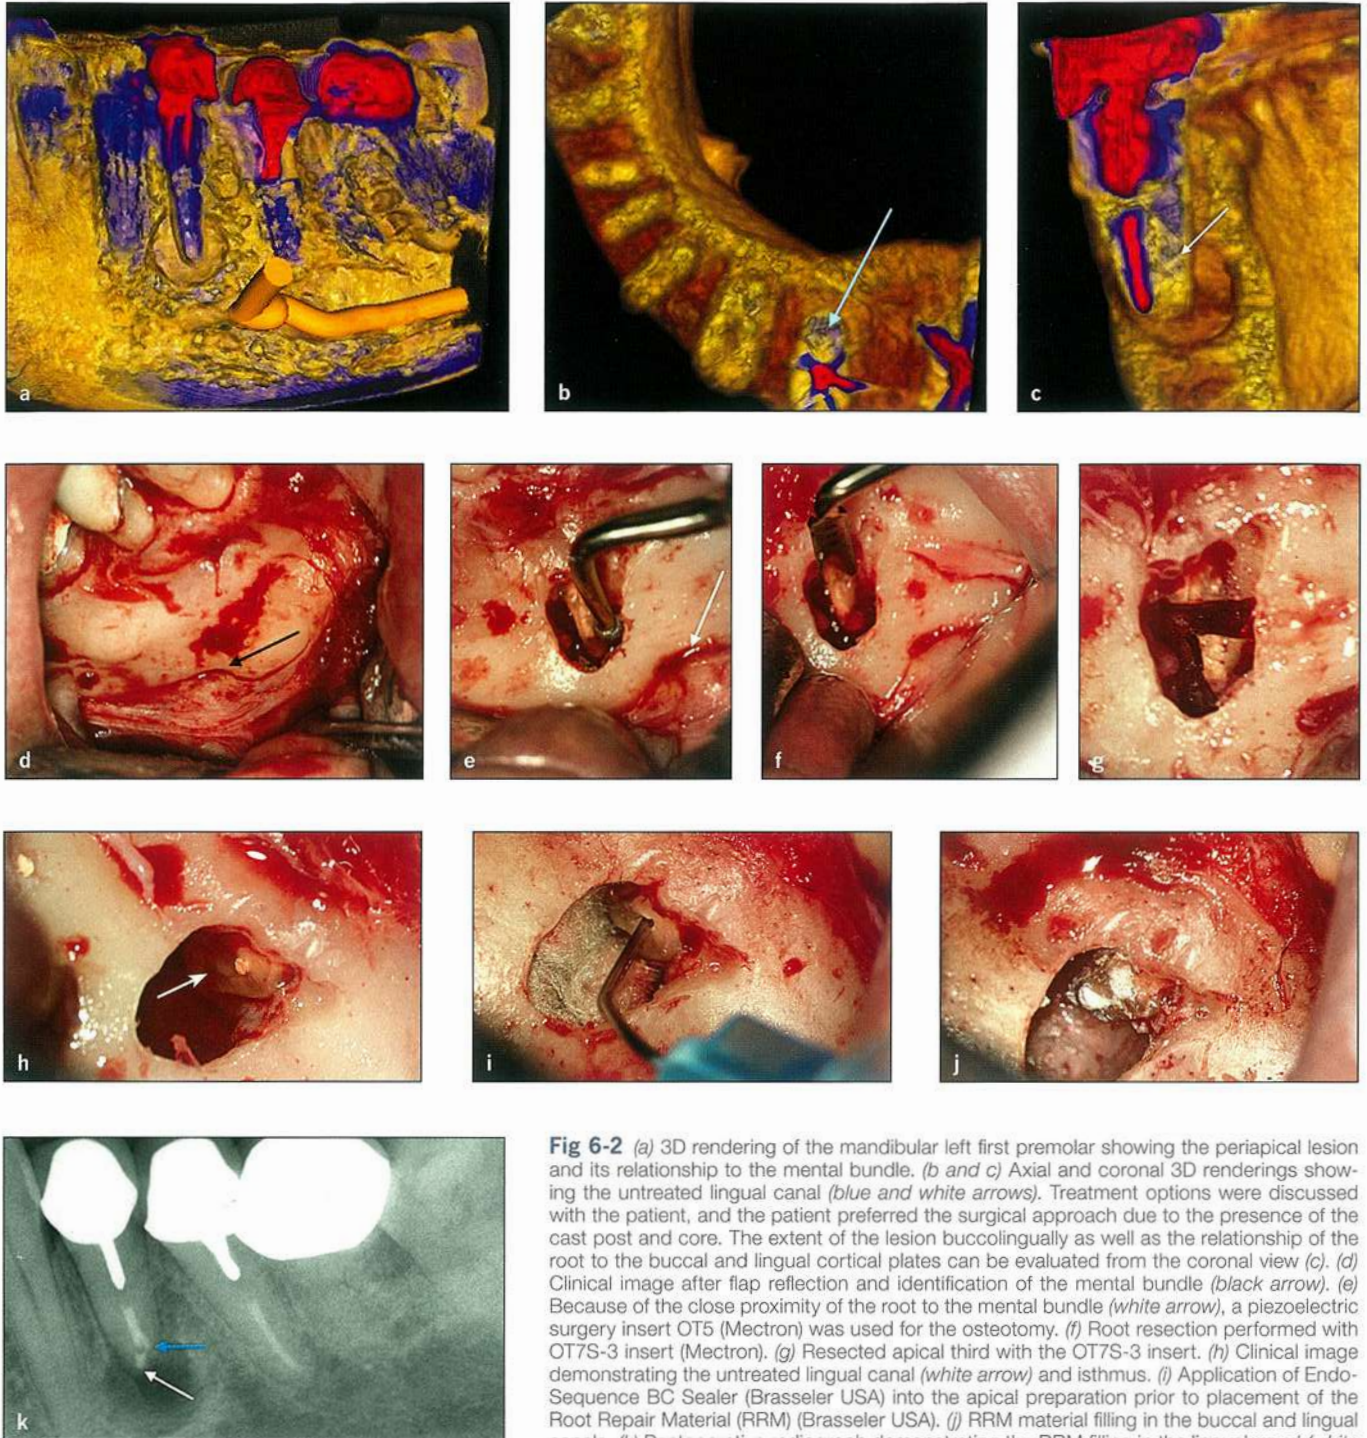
(a) 3D rendering of the mandibular left first premolar showing the periapical lesion and its relationship to the mental bundle. (b and c) Axial and coronal 3D renderings showing the untreated lingual canal (blue and white arrows). Treatment options were discussed with the patient, and the patient preferred the surgical approach due to the presence of the cast post and core. The extent of the lesion buccolingually as well as the relationship of the root to the buccal and lingual cortical plates can be evaluated from the coronal view (c). (d) Clinical image after flap reflection and identification of the mental bundle (black arrow). (e) Because of the close proximity of the root to the mental bundle (white arrow), a piezoelectric surgery insert OT5 (Mectron) was used for the osteotomy. (f) Root resection performed with OT7S-3 insert (Mectron). (g) Resected apical third with the OT7S-3 insert. (h) Clinical image demonstrating the untreated lingual canal (white arrow) and isthmus. (i) Application of Endo-Sequence BC Sealer (Brasseler USA) into the apical preparation prior to placement of the Root Repair Material (RRM) (Brasseler USA). (j) RRM material filling in the buccal and lingual canals. (k) Postoperative radiograph demonstrating the RRM filling in the lingual canal (white arrow) and buccal canal (blue arrow).
